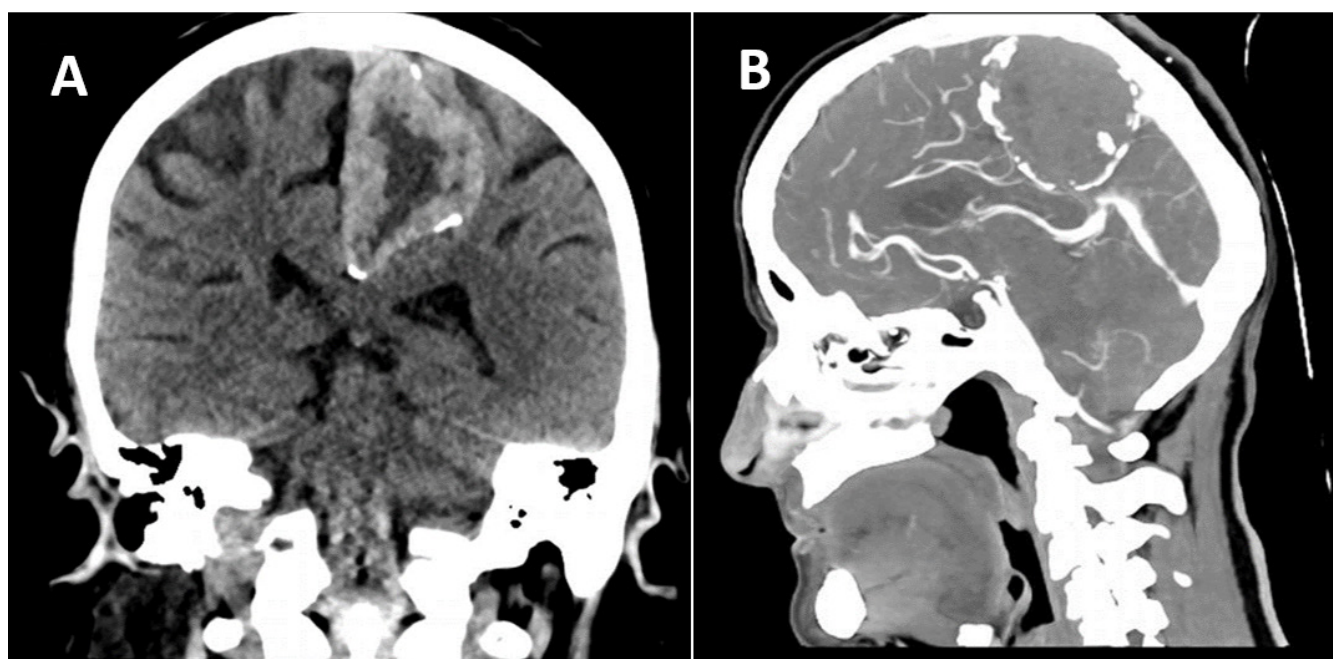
Preoperative CT images. A. Irregular calcifications in the coronal CT section. B. Avascular nature of the mass in the sagittal CT section.
